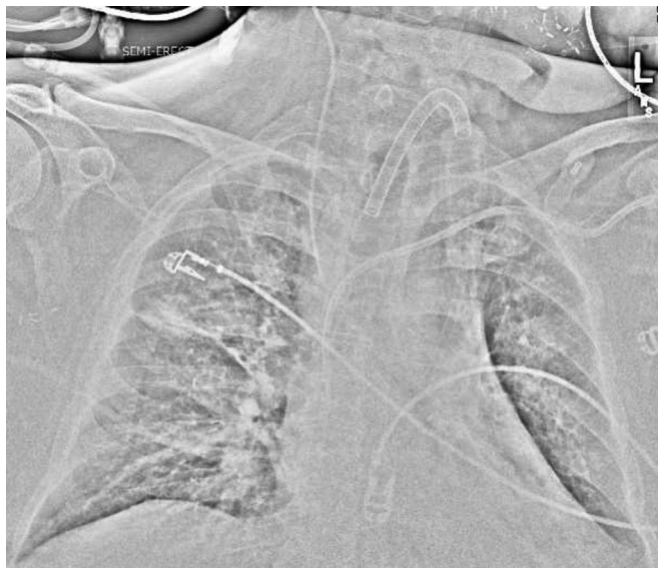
Plain film of the chest upon admission to our institution. Note the slight subsegmental atelectasis of the midright lung, mild increase in atelectasis of the medial bases (left greater than right), and concern for superimposed infiltrates/infection and small left pleural effusion.
